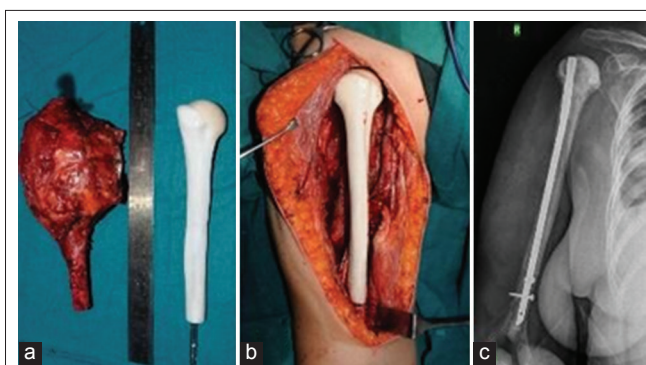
Excised tumor with barium sulfate loaded custom made acrylic prosthesis (a), Implanted acrylic prosthesis after tumor resection (b), Plain radiograph showing prosthesis *in situ* (c).
